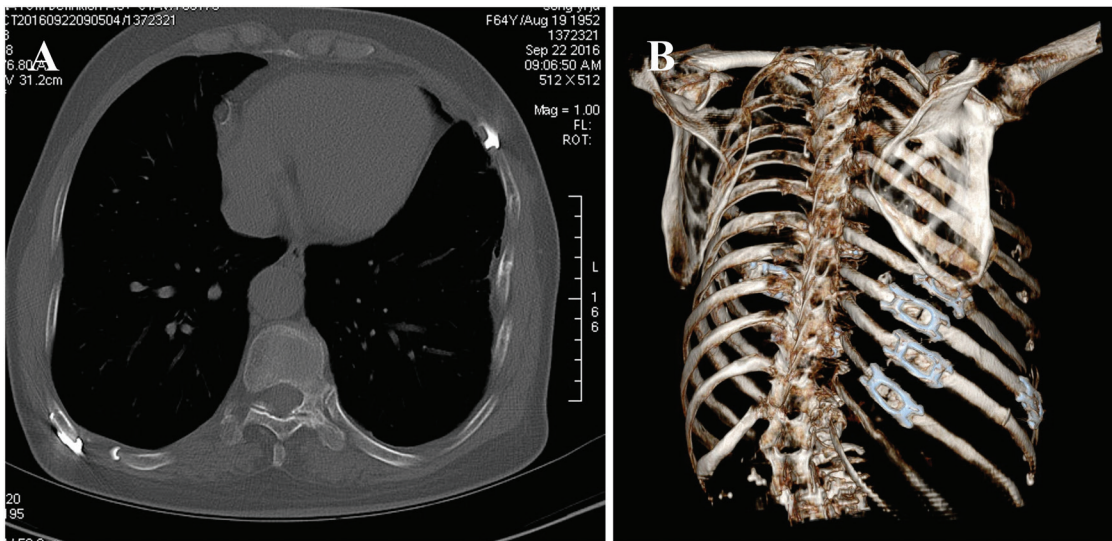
The follow-up chest CT of a multiple rib fractures accompanied with pulmonary contusion patient who receive surgical treatment. (A) transverse plane, (B) three-dimensional reconstruction. CT: computed tomography
